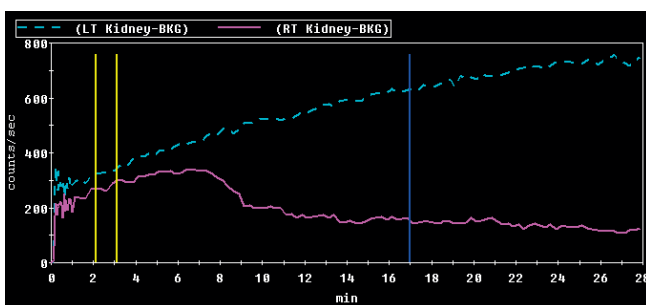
Obstructive type of renoscintigraphic curve – increasing activity in the left kidney throughout 28-min acquisition. No reaction to the diuretic administered in the 17th minute
